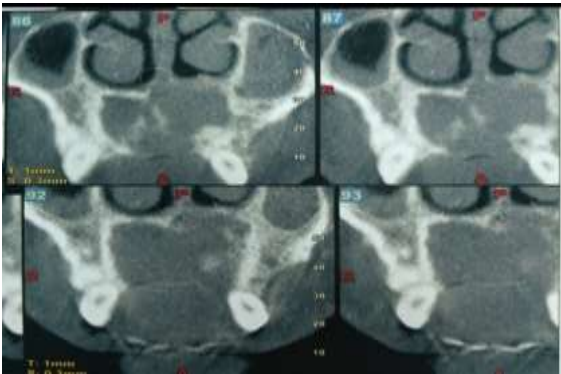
CBCT showing mucosal thickening of maxillary sinus
